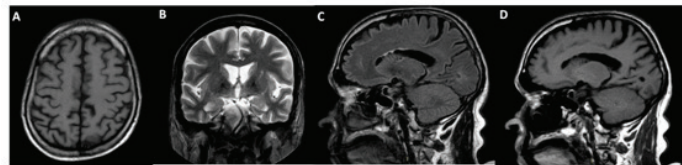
T1-weighted axial (A), T2-weighted coronal (B), FLAIR (C) and T1-weighted (D) sagittal brain MRI, highlighting global brain atrophy, inconspicuously more pronounced in parietotemporal regions, with enlargement of lateral ventricles. A 68-year-old man, merchant, with gradual lapses progressing for eight months. He forgets goods orders and important events, impacting work. In the last three months, he started presenting a poor speech with few words, many nightmares and visual hallucinations. These characteristics fluctuate during the day. He reached 18 points on MEEM, which reveals a decline in executive and visuospatial functions. Neurological examination showed hypomimia, bradykinesia, symmetrical cogwheel rigidity of upper limbs, reduced verbal fluency and several paraphasias. Potentially reversible dementias screening was negative. The sum of clinical and radiological characteristics allowed the diagnosis of DCL.
